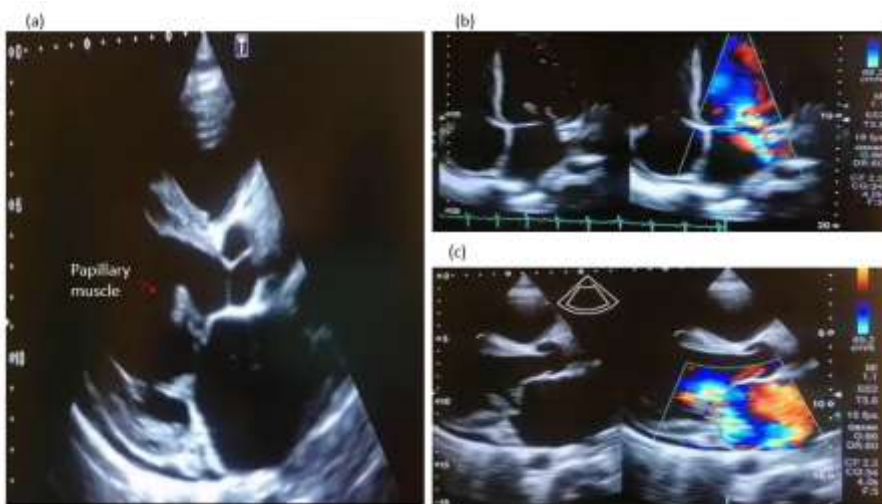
Transthoracic echocardiogram showing (a) thickened mitral valve leaflets, diastolic doming of the anterior mitral valve, some degree of thickening of the subvalvular apparatus, and a stump-like papillary muscle at the tip of the anterior mitral valve leaflet in the parasternal long axis view. (b and c) Colour-flow Doppler imaging shows a posteriorly directed jet of severe mitral regurgitation.
